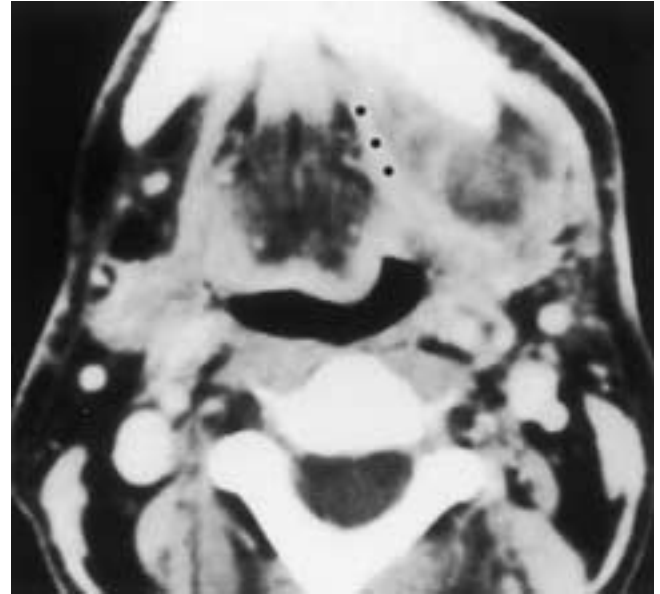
Submandibular space abscess. Axial CT scan demonstrates a large submandibular space abscess on the left, limited externally by the fibers of the platysma muscle. The abscess displaces the left mylohyoid muscle (*black dots*) medially and superiorly. (Courtesy of Dr. Deborah Reede.)
